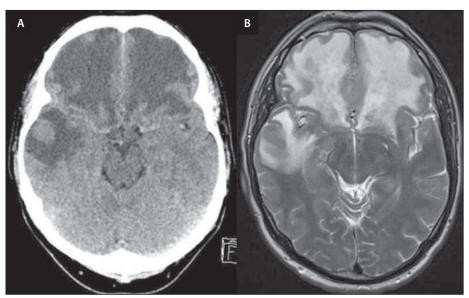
(A) Non-contrast CT, (B) MRI, T2 weighted image – extensive areas of vasogenic edema in both frontal and the right temporal lobe.
